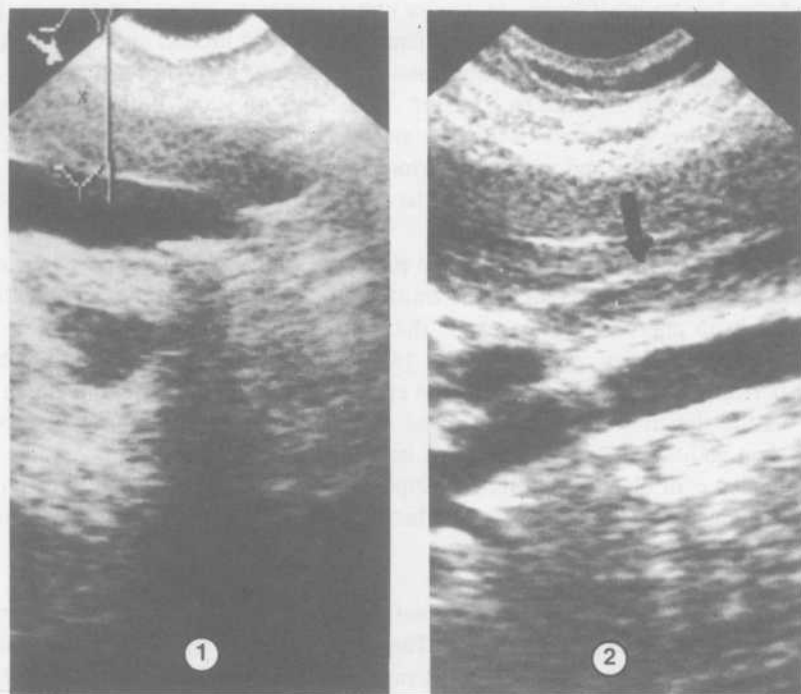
4: Plate 1. Ultrasound appearance of the gallbladder before ablation (patient no. 8). Plate 2: The gall bladder region (arrow) is showing a 1 cm wide echogenic structure. No lumen was seen (patient no. 8).
